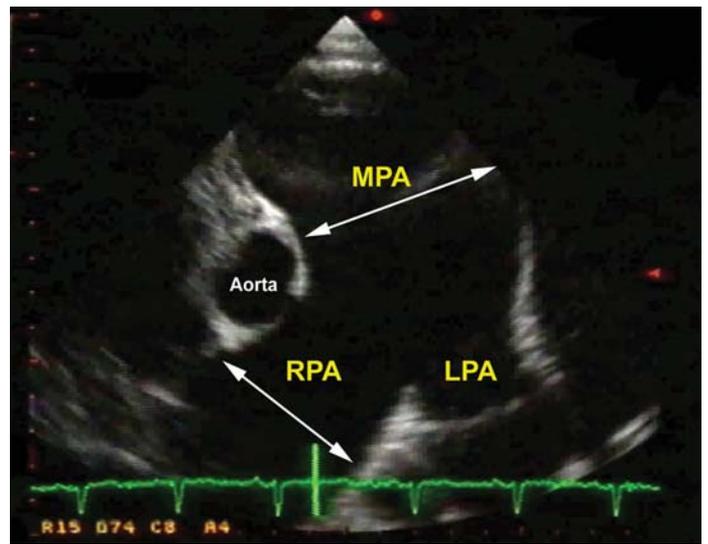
Right ventricular outflow tract and main pulmonary artery dimensions from the parasternal short axis view. The diameter of the main (MPA), the right (RPA), or the left (LPA) pulmonary artery should not exceed 2.5 cm. In this view, an aneurysm of the central pulmonary arteries could be detected as well.
